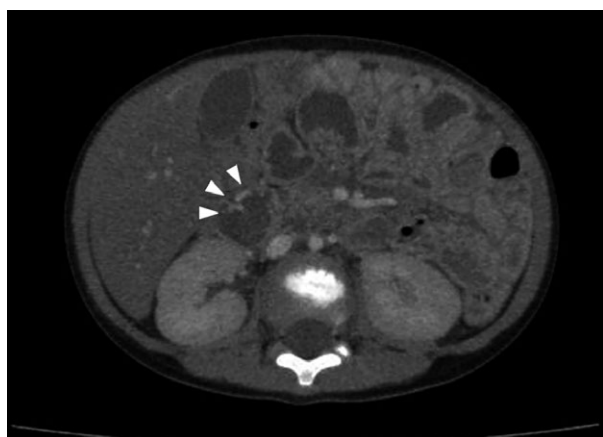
Computed tomography shows bleeding at the descending part of duodenum (arrowheads) in a 2-year-old boy, resulting from norovirus gastroenteritis.
